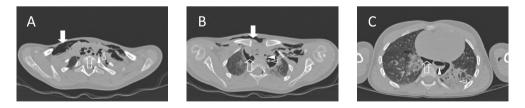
Axial computed tomography (CT) scan in lung setting. This shows subcutaneous emphysema (solid arrow), air in the trachea (open arrow) with air in the adjacent esophagus, and air surrounding the left common carotid artery (solid arrowhead) and left jugular vein (open arrowhead). Figure 2b. Axial CT scan in lung setting. This shows subcutaneous emphysema (solid arrow), pneumomediastinum (open arrow), and air surrounding the left common carotid artery (solid arrowhead) and left subclavian artery (open arrowhead). Figure 2c. Axial CT scan in lung setting. This shows pneumomediastinum (open arrow), air fluid level in the esophagus (solid arrowhead), and postmortem consolidation of lung parenchyma (open arrowhead).
